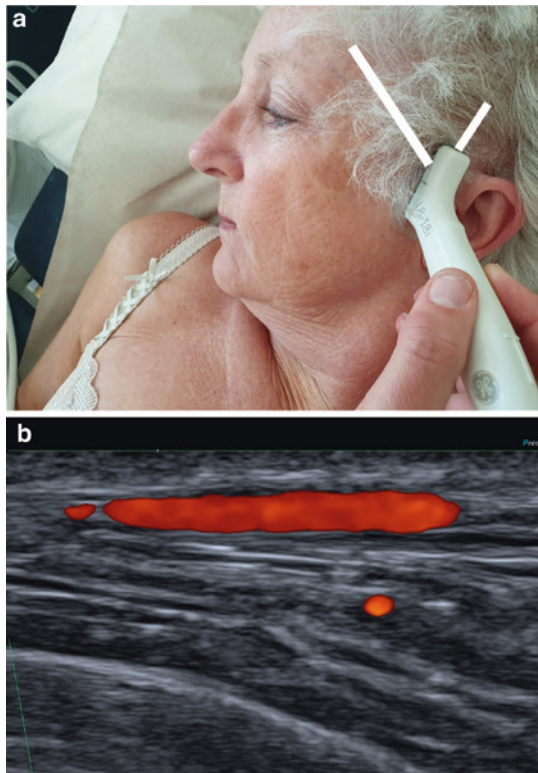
Examination of the common temporal artery: a position of the transducer, b ultrasound image, longitudinal view
